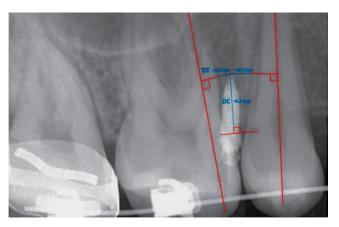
Radiographic evaluation using a periapical radiograph. Source: Haddad et al.², 2019.
